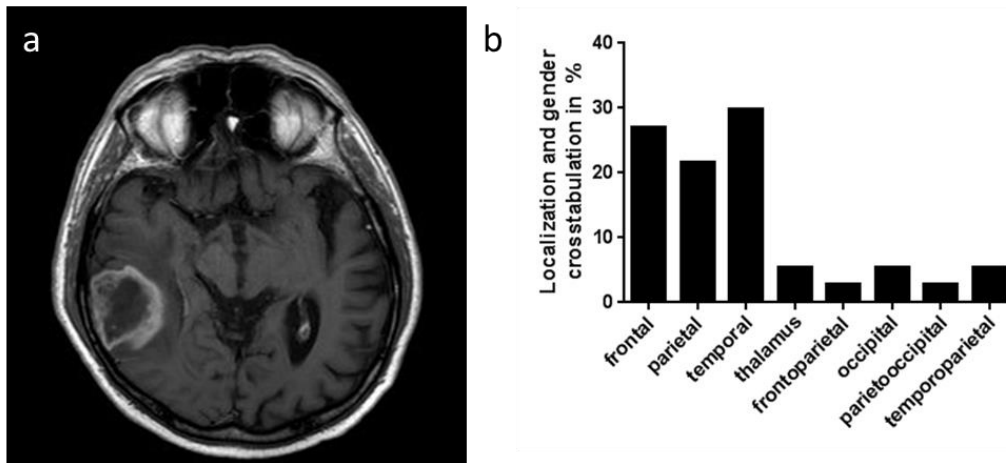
(a) T1-weighted gadolinium enhanced cranial axial image with a typical glioblastoma (GB) in the right dorsal temporal lobe. (b) Frequency of localization of GB in % is shown. Most tumors were found in the frontal, parietal, and temporal lobe of the patients.
